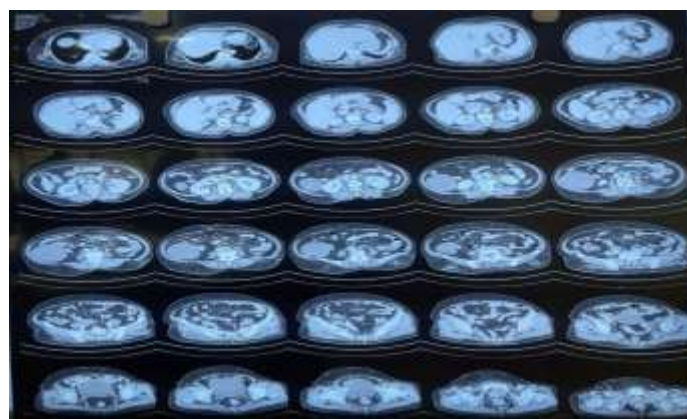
Contrast-enhanced CT of the abdomen and pelvis showing a unilocular retroperitoneal cystic lesion adjacent to the ascending colon.
